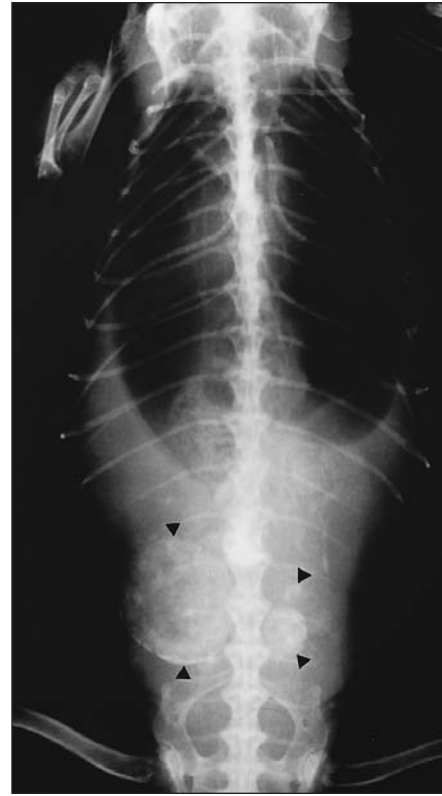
Same radiographic views as in Figure 1. Several masses of various sizes and radiopacities are evident in the caudal region of the coelom (arrowheads).
